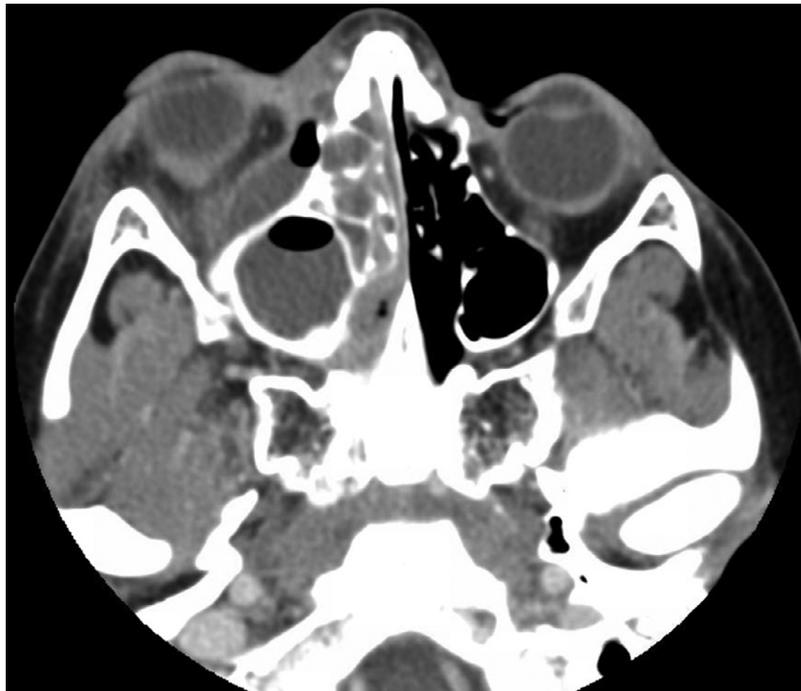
A computed tomography scan showing a large, gas-containing inferomedial subperiosteal abscess, associated with a right-sided pansinusitis and orbital cellulitis.
